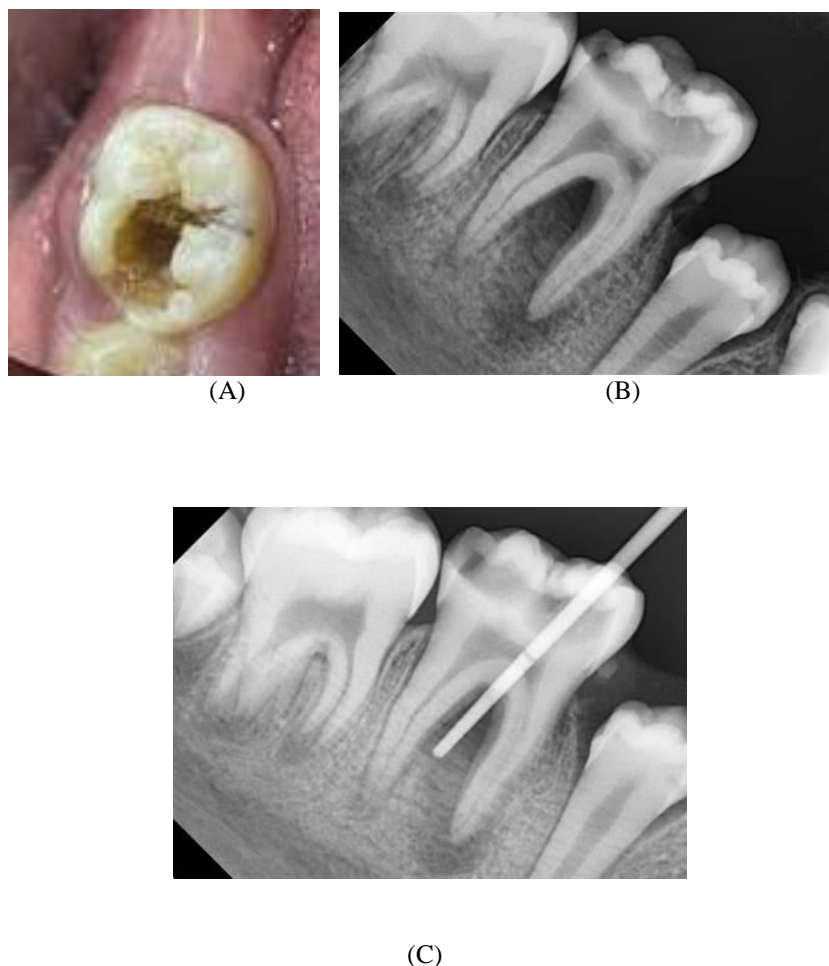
A. Clinical photograph of tooth #46. B. Periapical radiograph : furcation bone and apical bone destruction in mesial root. C. Sinus tract was traced with gutta percha
